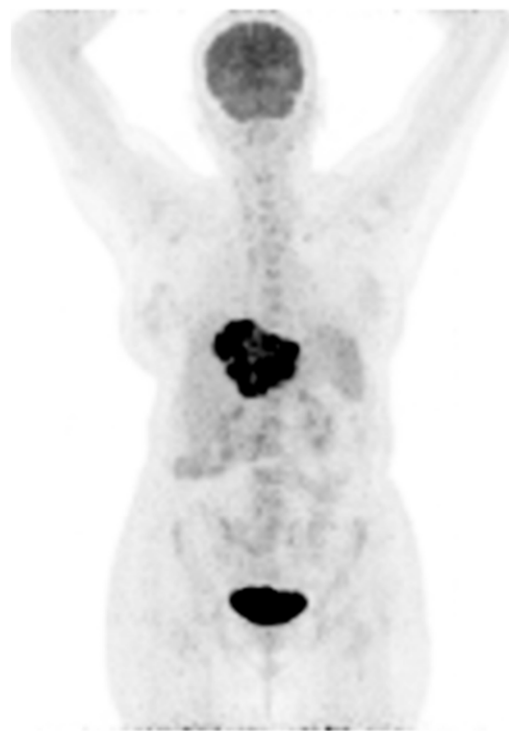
Maximum intensity projection of pre-treatment PET image showing intense FDG uptake in the liver lesion with no other focus of abnormal FDG identified elsewhere in the body.
